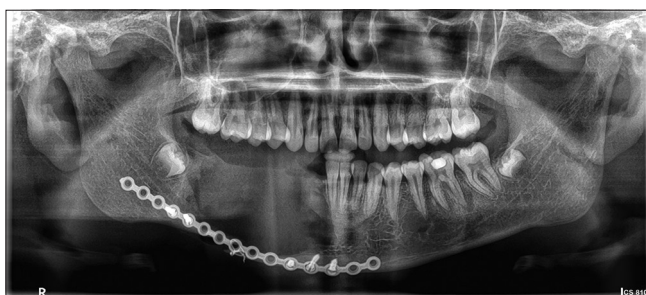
Orthopantomogram depicting transosseous wiring and reconstruction plate placement to maintain the continuity of the lower border of the mandible
